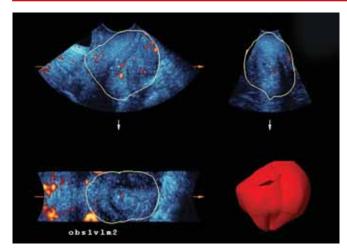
Transvaginal 3D US power Doppler assessment of the cervix. Cervical volume and vascularization can be calculated easily using the virtual organ computer-aided analysis (VOCAL) program
